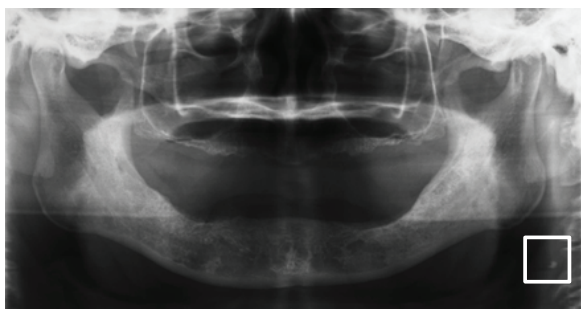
Example of the candidate region on the dental panoramic radiograph.
